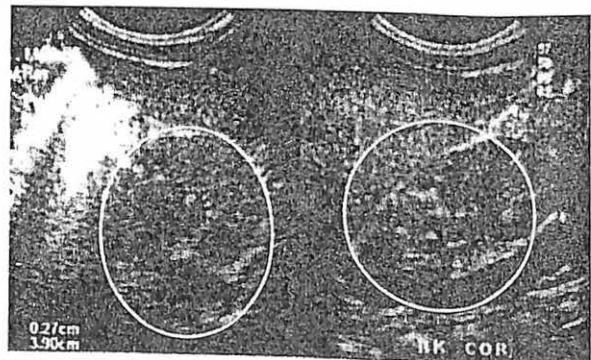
Ultrasound of the kidneys of patient 3 showing bilateral pelvicalyceal system dilatation (circle).
